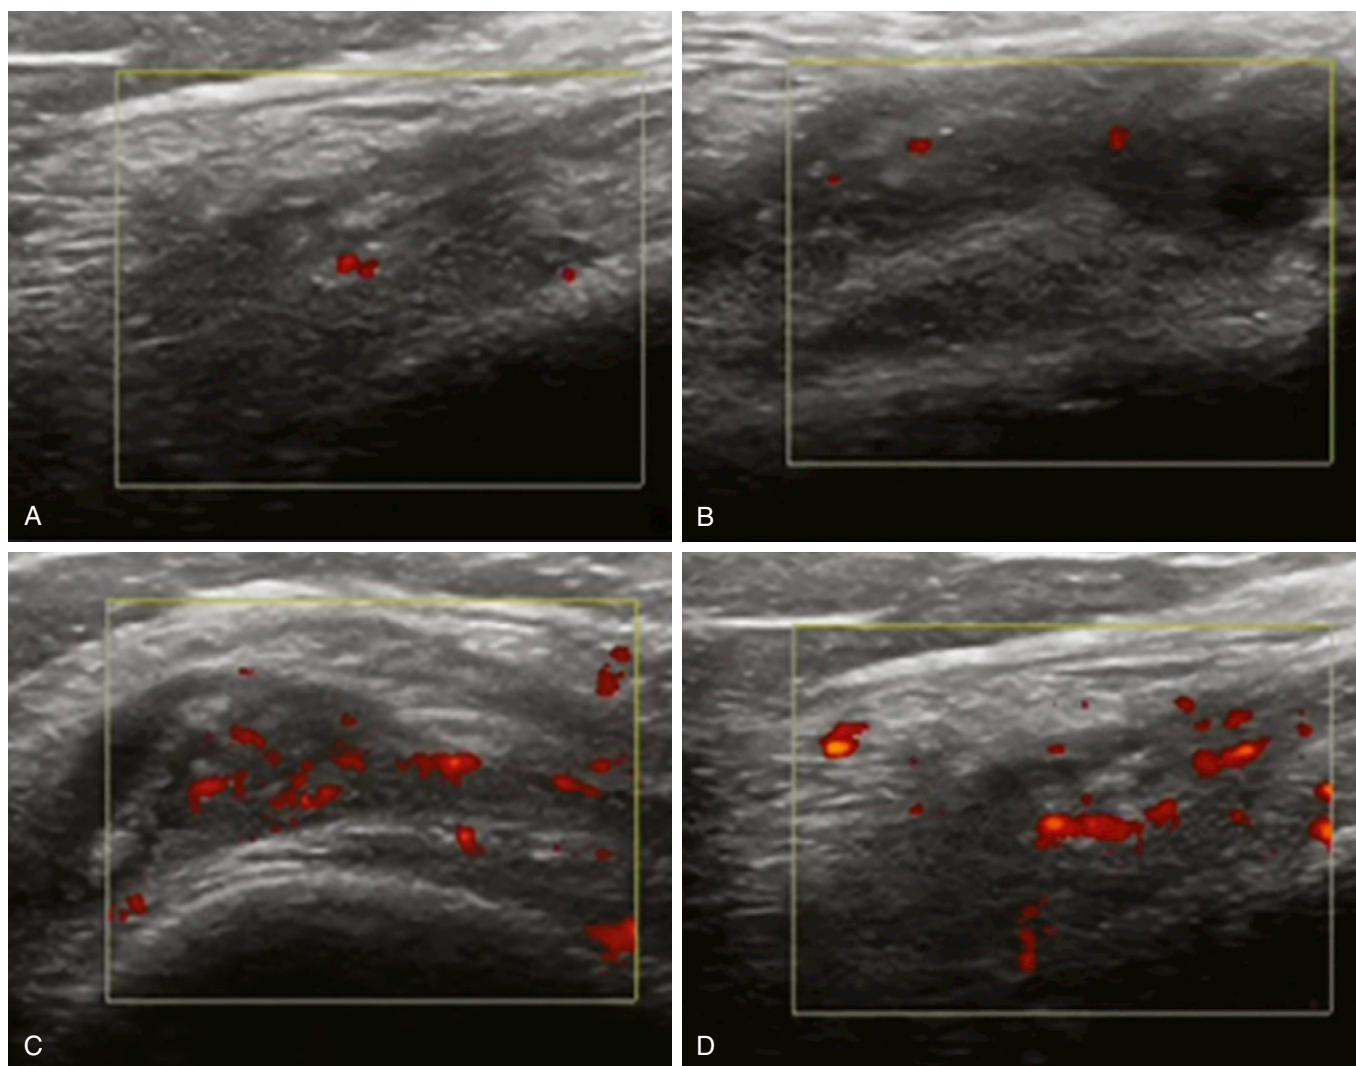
Power Doppler ultrasound shows the suprapatellar and parapatellar recesses in the knee of a patient with osteoarthritis. Mild (A and B) and moderate (C and D) hyperperfusion indicates active inflammation.
